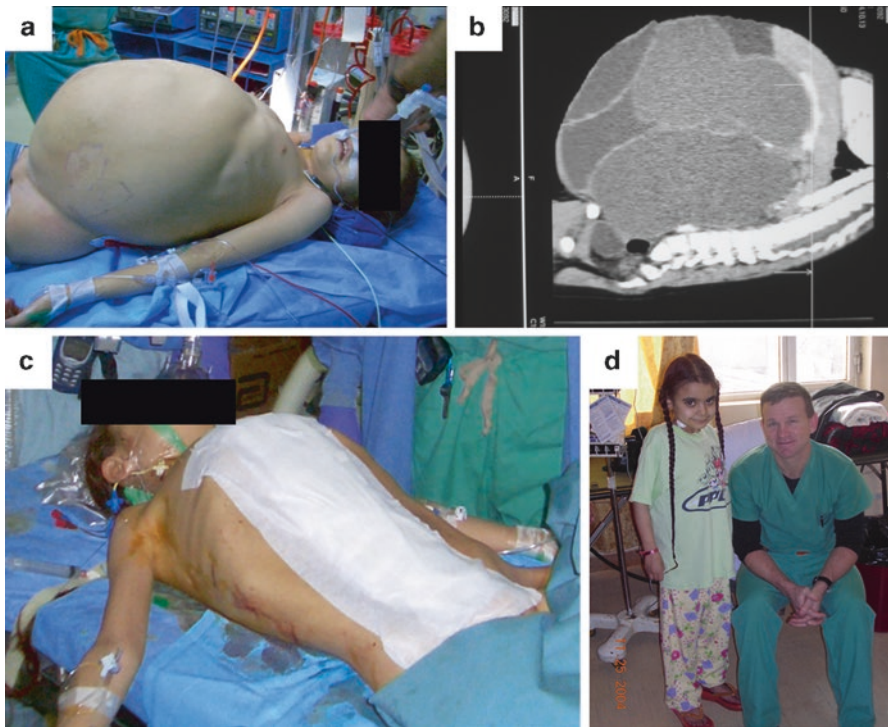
(a) Young Iraqi female with massively distended abdomen; (b) giant cystic abdominal mass on CT scan; (c) same patient following laparotomy and mass resection; (d) posing with her surgeon, LTC Tommy Brown, on the inpatient ward after surgery
